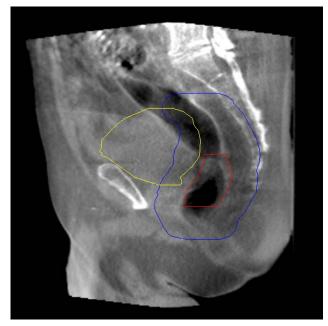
CBCT image demonstrating the potential impact of having a large rectal size due to gas.
